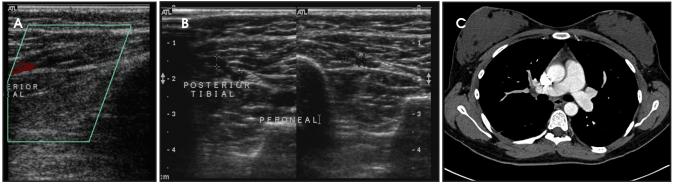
A 34-year-old post-partum woman with fever and oxygen desaturation. Initial lower extremity sonography demonstrated no DVT in the thighs, but DVT was present in branches of the posterior left tibial vein, a deep calf vein. Sagittal Color Doppler image (A) and transverse gray scale images (B) without (left) and with (right) compression reveal no flow in the veins and lack of compressibility (calipers, B). CT pulmonary angiography (without venography) was then performed, which shows a right upper lobe embolism (C). There were also right middle lobe emboli (not shown).
